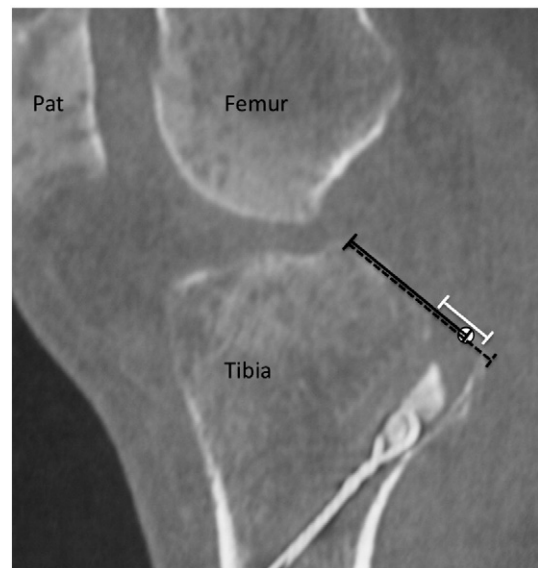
A sagittal plane computed tomography image of a left knee following arthroscopic posterior cruciate ligament (PCL) reconstruction. The centre of the entry point of the PCL tibial tunnel into the joint is noted with a white dot. The distance from the centre of the tunnel to the posterior border of the retrospinal surface was measured (solid black line), as was the total length of the retrospinal surface (dashed black line). The white line denotes the expected antero–posterior position: placement of the tunnel within 5 mm of the centre of the posterior half of the retrospinal surface. The femur, tibia, and patella (Pat) are labeled.
